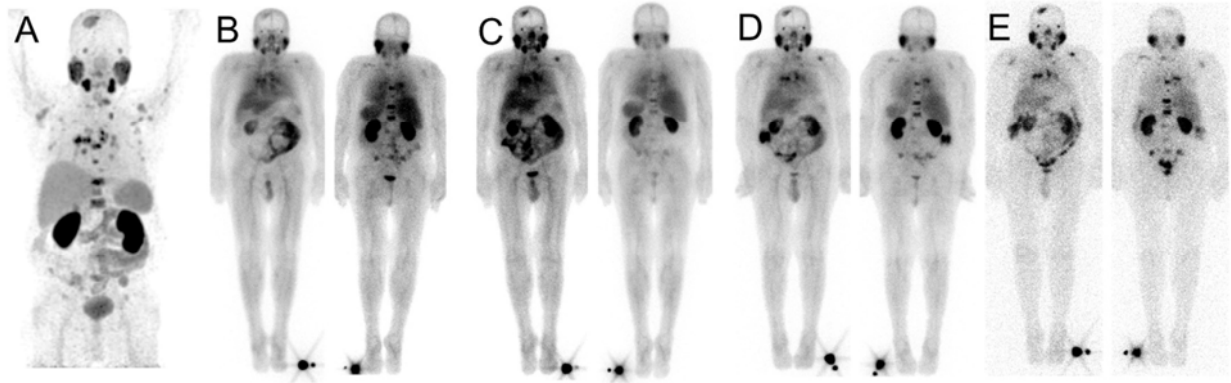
^{68}Ga -HBED-CC PSMA PET (A) and $^{99\text{m}}\text{Tc}$ -PSMA-I&S whole-body planar scintigraphy (B-E)
